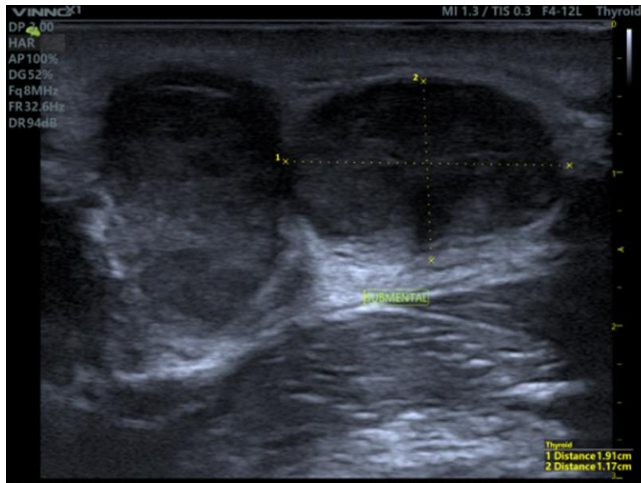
A sonogram of the submental gland taken using a linear probe shows multiple well-defined ovoid hypoechoic nodules in the submental gland with internal necrotic cystic areas - the largest measures 1.91x1.17 cm in AP diameter.
